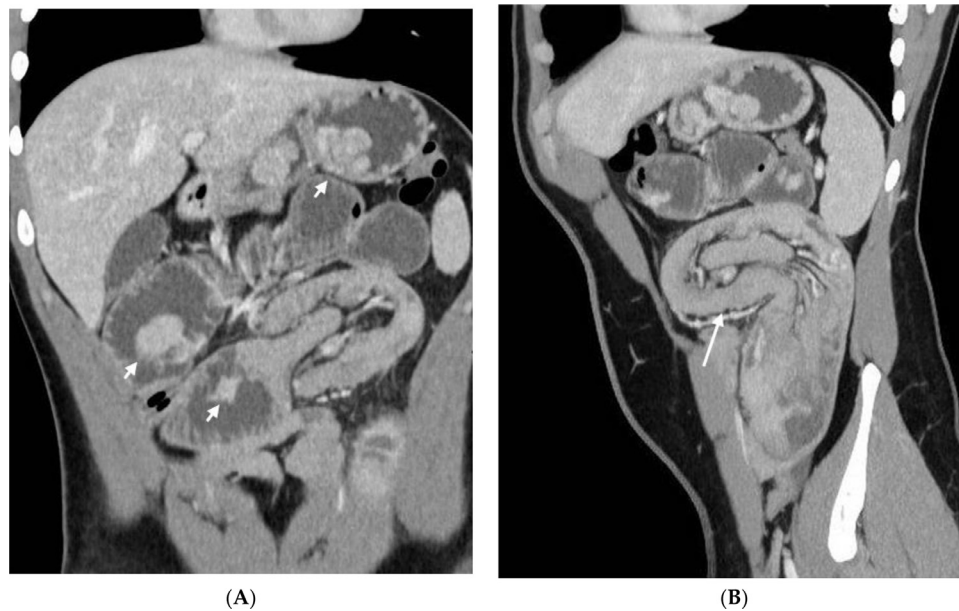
(A) Coronal CT image demonstrates multiple intestinal polyps throughout the stomach and small intestine; CT image shows also a segment of jejunum invaginating into an adjacent segment; image demonstrates multiple intestinal polyps throughout the stomach and small intestine (short arrows). (B) Sagittal CT reformatted image demonstrates the "sausage-shaped" or "reniform" mass (long arrow).
